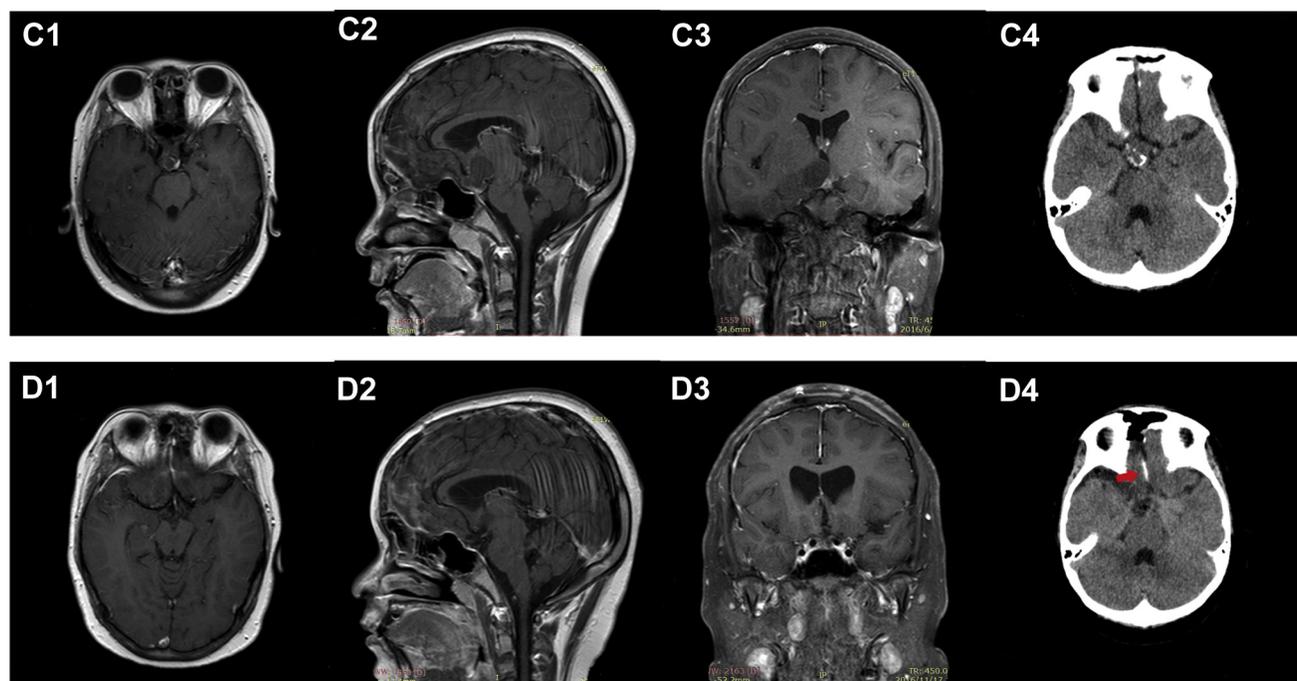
Follow-up magnetic resonance imaging revealed recurrence of the tumor 9 months after primary surgery. Magnetic resonance imaging showed that the lesion was mainly localized in the suprasellar. Part of the tumor invaded into the third ventricle and the obstructive hydrocephalus had disappeared (C1–C3). Calcification was found in the original location
